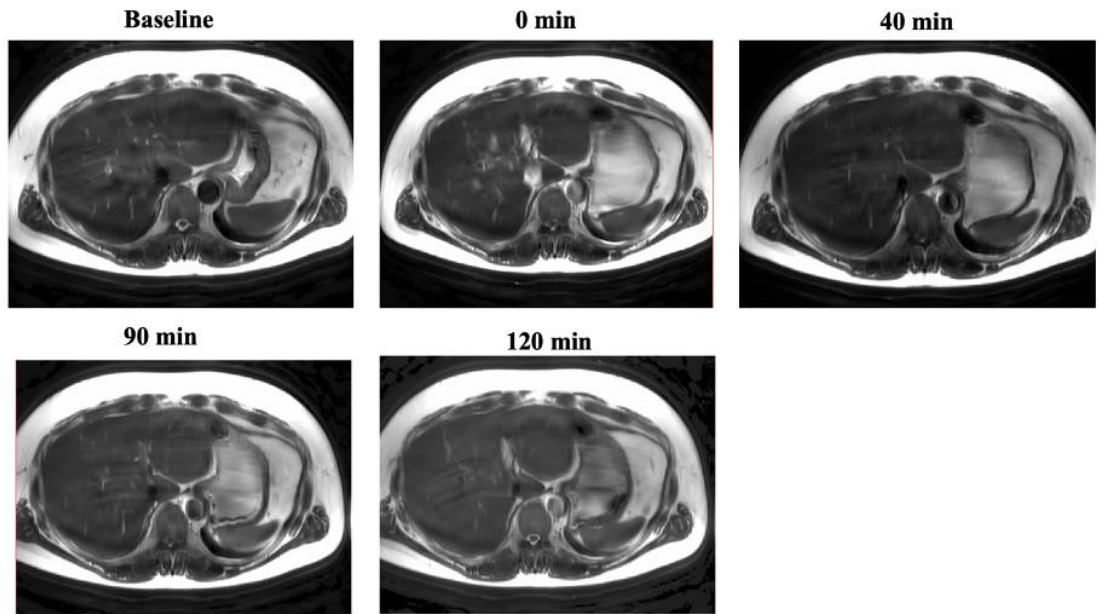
Examples of MRI scans of a participant with normal-weight showing the stomach at fasting/baseline and at different time points following the consumption of the high-fat and high-carbohydrate drinks.
